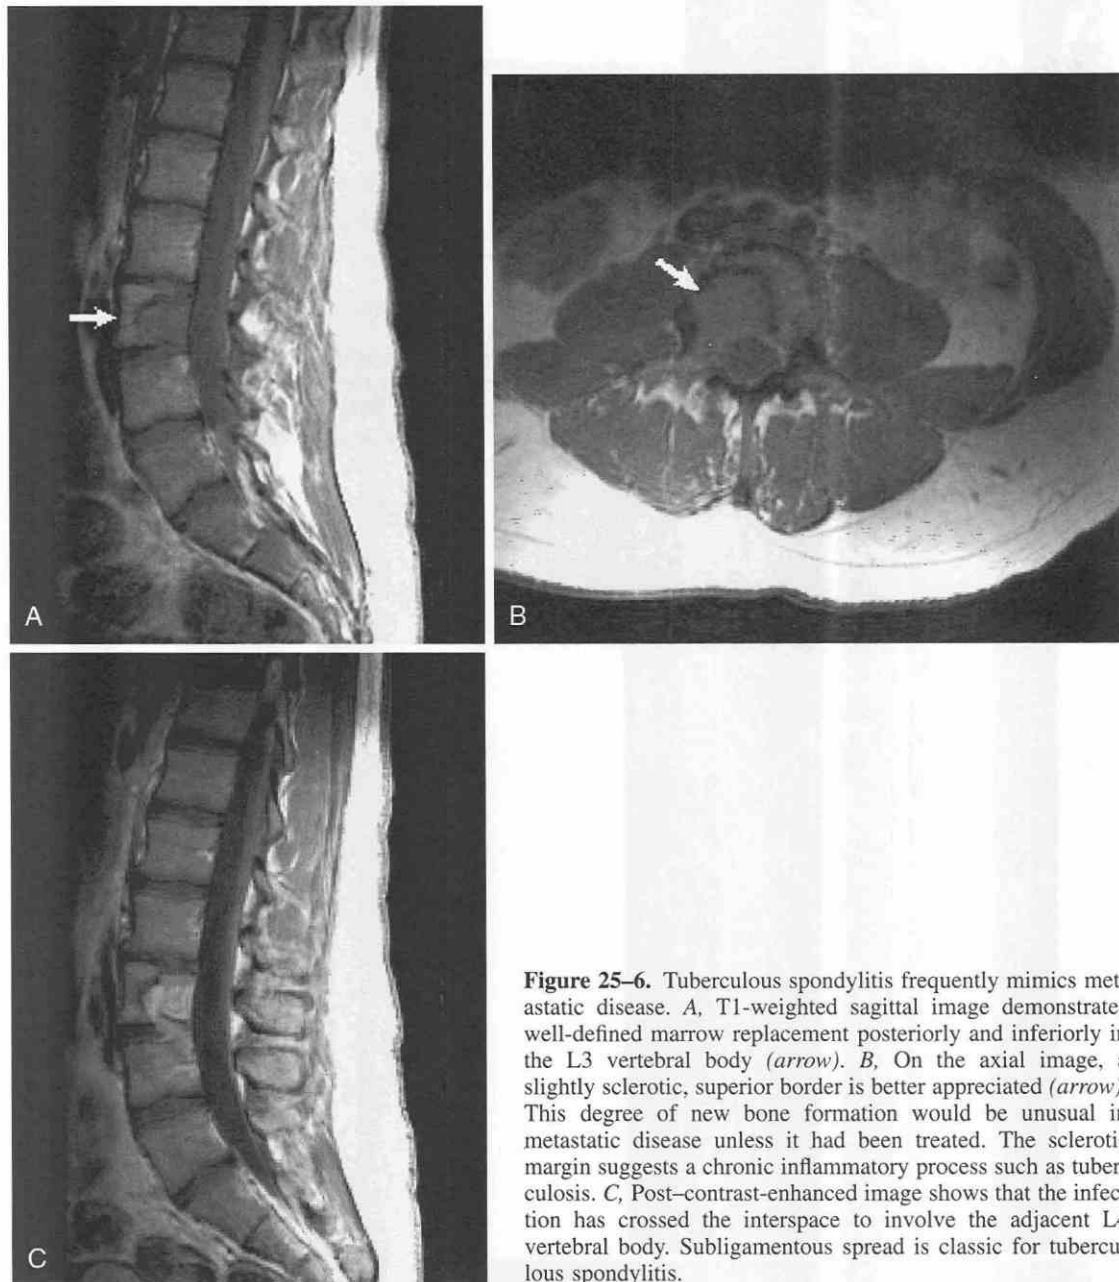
Tuberculous spondylitis frequently mimics metastatic disease. *A*, T1-weighted sagittal image demonstrates well-defined marrow replacement posteriorly and inferiorly in the L3 vertebral body (*arrow*). *B*, On the axial image, a slightly sclerotic, superior border is better appreciated (*arrow*). This degree of new bone formation would be unusual in metastatic disease unless it had been treated. The sclerotic margin suggests a chronic inflammatory process such as tuberculosis. *C*, Post-contrast-enhanced image shows that the infection has crossed the interspace to involve the adjacent L4 vertebral body. Subligamentous spread is classic for tuberculous spondylitis.
